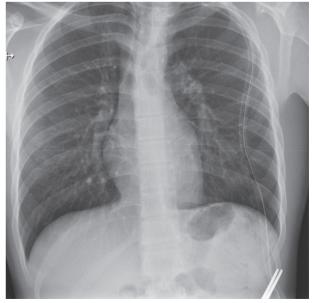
Chest X-ray with complete left pulmonary expansion
